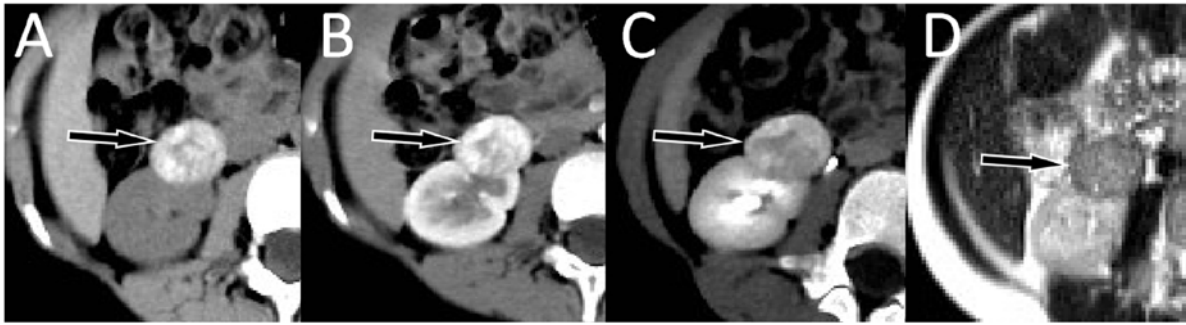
Scan images of the patient's mass. (A) Computed tomography plain scan showed an uneven high-density mass about 2.0x2.4x3.0 cm in size in the lower pole of the right kidney, protruding outside the outline of the kidney. (B) Contrast-enhanced cortical phase showed marked enhancement of the lesion, similar to that of the adjacent renal cortex. (C) Decreased degree of enhancement in the medullary phase. (D) T2-weighted imaging sequence of magnetic resonance imaging showed that the signal of the lesion was slightly lower than that of the adjacent renal parenchyma.
